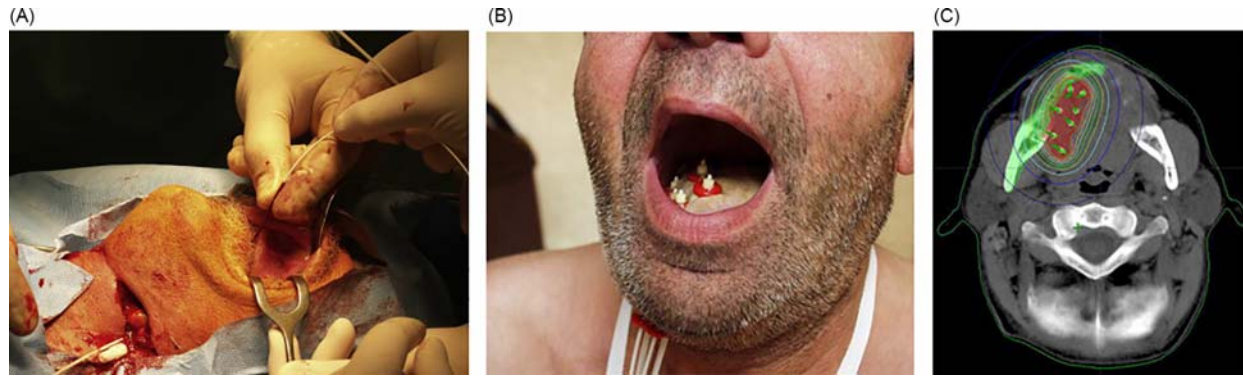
(A) Technique of afterloading catheters insertion. (B) Implantation of afterloading catheters. (C) CT-based planning of dose distribution. From Tuček L, Petera J, Sirák I, Vošmik M, Doležalová H, Brokešová S, Hodek M, Kašáková L, Paluska P. (2011) Hyperfractionated high-dose rate brachytherapy in the treatment of oral tongue cancer. *Reports of Practical Oncology and Radiotherapy* 16(6), 243–247.
